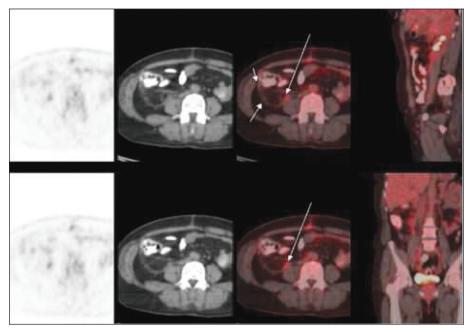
Postoperative positron emission tomography/computed tomography imaging at the fifth week. An increase in intensity was observed in the lower right side of the abdomen, starting from the lower pole of the kidney and leaning on the psoas major muscle, which was accompanied by slight fluorodeoxyglucose uptake, as well as giving the impression of continuity with the lateral infrarenal fatty planes. The findings were reported as suspicious for residual malignant processes following surgery.
